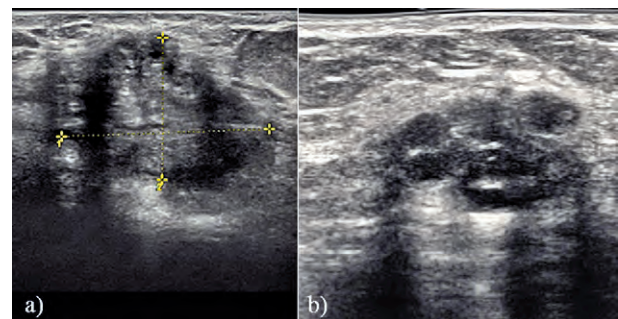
a) Transverse sonogram of the abdominal wall showing a 33/22-mm abdominal wall endometriosis nodule with hypoechoic content and blurred outer margins (calipers). The nodule is enclosed in the subcutaneous fatty tissue above the muscular fascia, along the scar of a previous Cesarean section; b) Transverse sonogram of the abdominal wall showing a nodule with hypoechoic content and cystic images.
